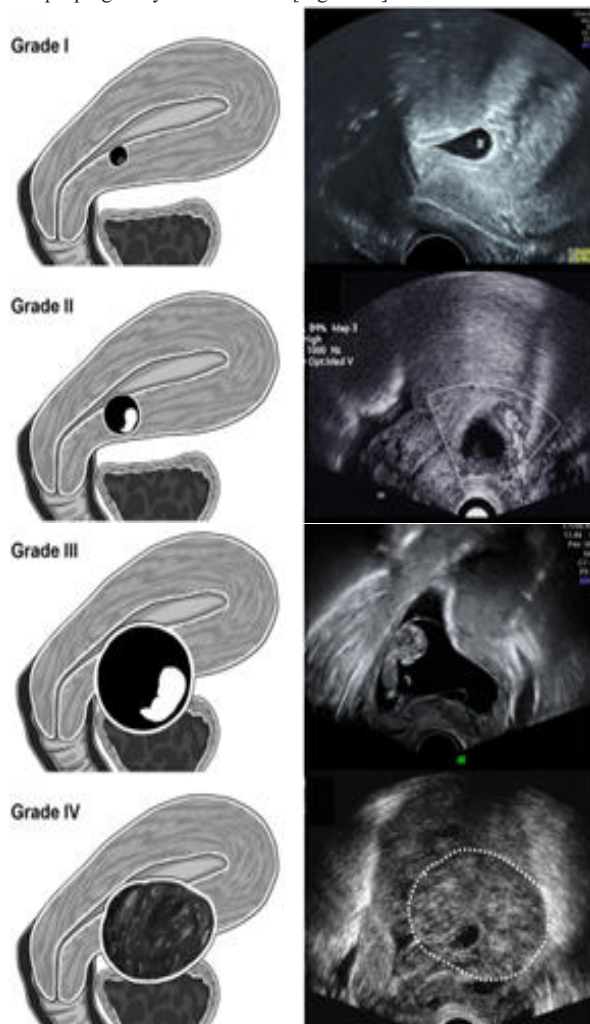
New ultrasound grading system for CSEP Grade I CSEP represented the depth of CSEP embedded in less than one-half thickness of the lower anterior corpus. Grade II CSEP implied CSEP occupied more than one-half thickness of the lower anterior corpus. In grade III CSEP, the GS bulged out the overlying myometrium and uterine serosa. In grade IV CSEP, the GS became an amorphous tumor with rich vascularity at the cesarean scar¹³
